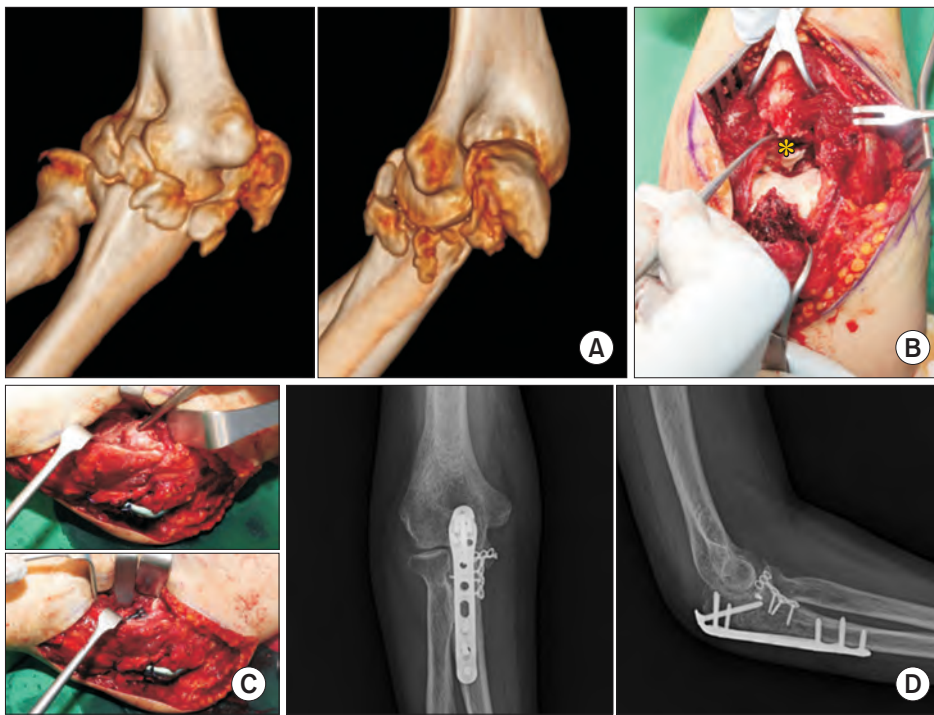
A 70-year-old woman classified as having a type 1 trans-ulnar basal coronoid fracture-dislocation. (A) Three-dimensional computed tomography reconstruction of the type 1 trans-ulnar basal coronoid fracture-dislocation. (B) Anteromedial facet fragment (AMF) fractures (asterisk) were seen through the posterior approach. However, it was hard to reduce and fix through this approach. (C) After reduction of olecranon fracture, AMF fracture was anatomically reduced through the over-the-top approach with mini-plate. (D) Postoperative anteroposterior and lateral radiographs at the final follow-up.
